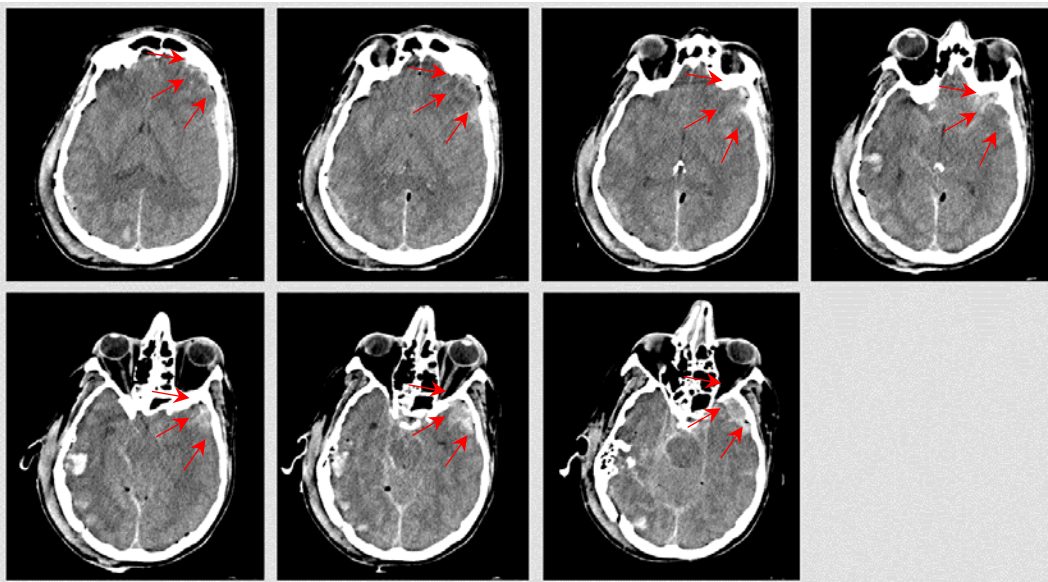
Head injuries – impact against road sign (please remind that CT image is reversed (mirrored)).
